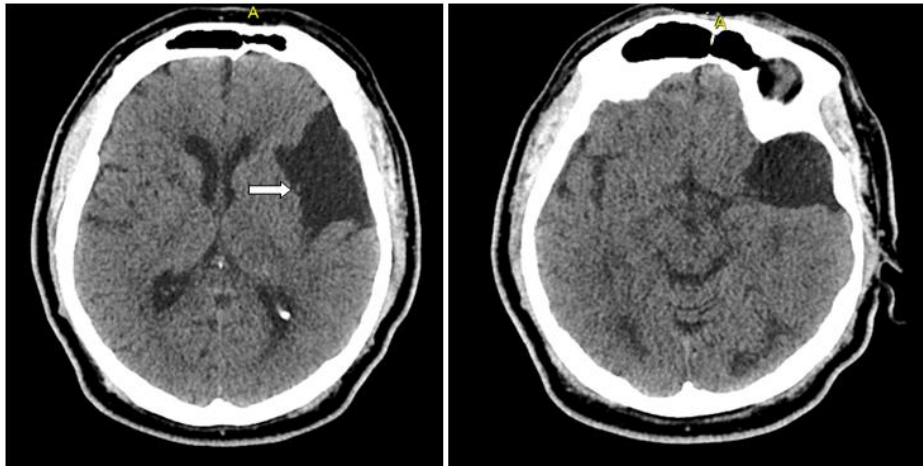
The cranial CT showed no pathological finding except an arachnoid cyst in the left sylvian fissure location (arrow), no CT finding compatible with infarct was detected
